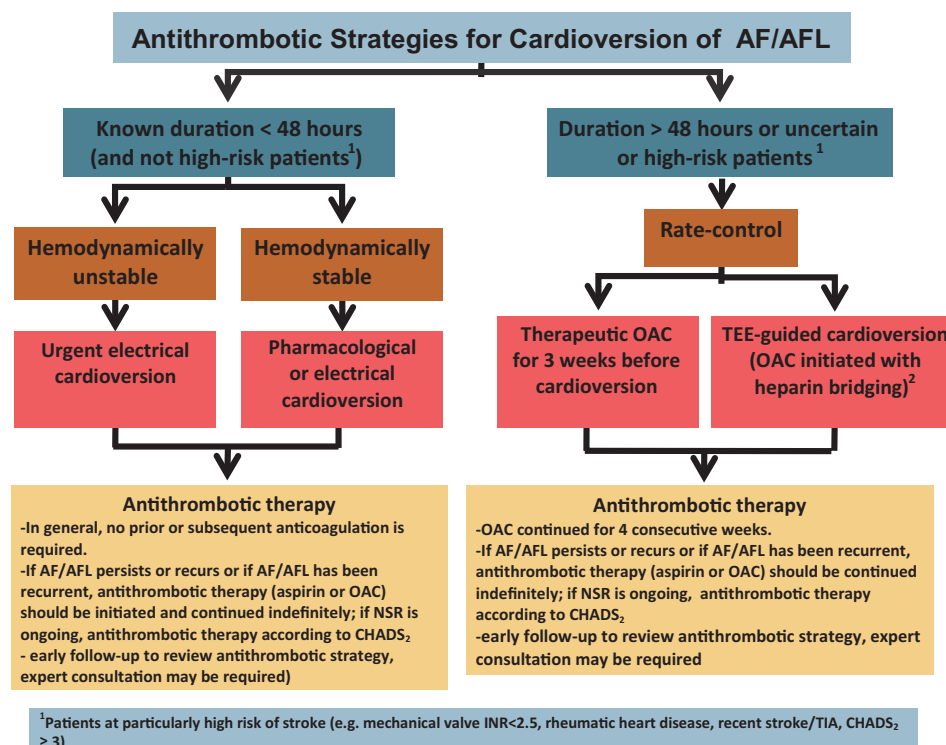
A summary of our recommended strategies for antithrombotic therapy in conjunction with cardioversion. CHADS₂, please see Table 1; INR, international normalized ratio; NSR, normal sinus rhythm; OAC, oral anticoagulant; TEE, transesophageal echocardiography; TIA, transient ischemic attack.
